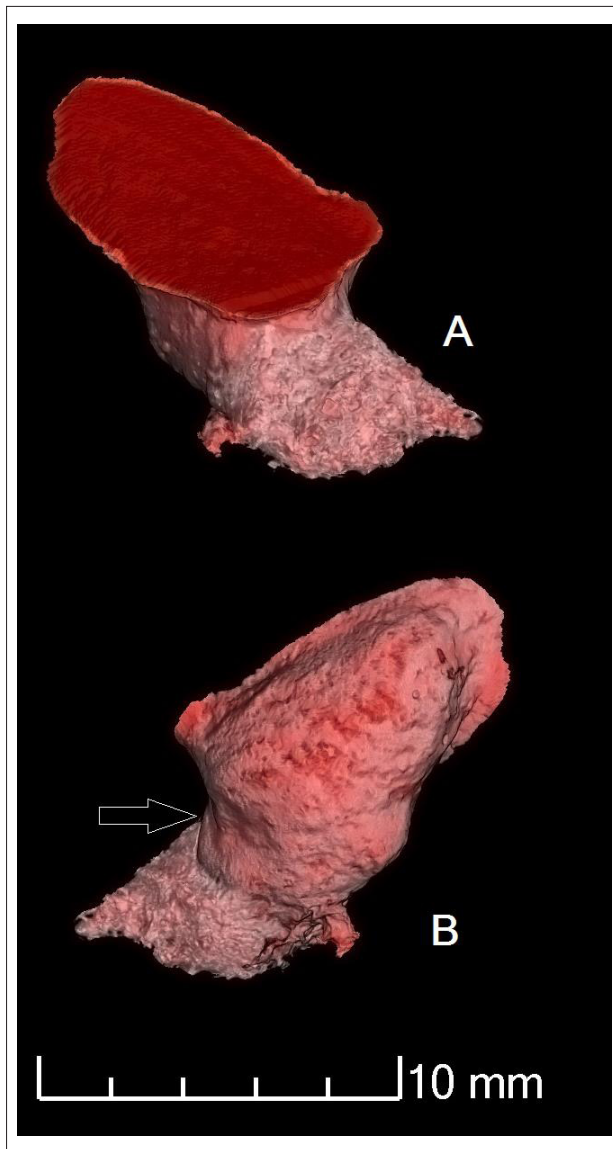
Surface rendered image volume of the U.W. 88-37 lesion derived from phase-contrast X-ray synchrotron microtomography. Images show isosurface derived from segmented boundaries of the lesion (remaining breccia infill removed). The arrow denotes the interface between the smoother dorsal sclerotic zone and the disorganised ventral lytic zone within the body of the lesion. (a) right lateral view, (b) medial view. Images produced by P.T.
